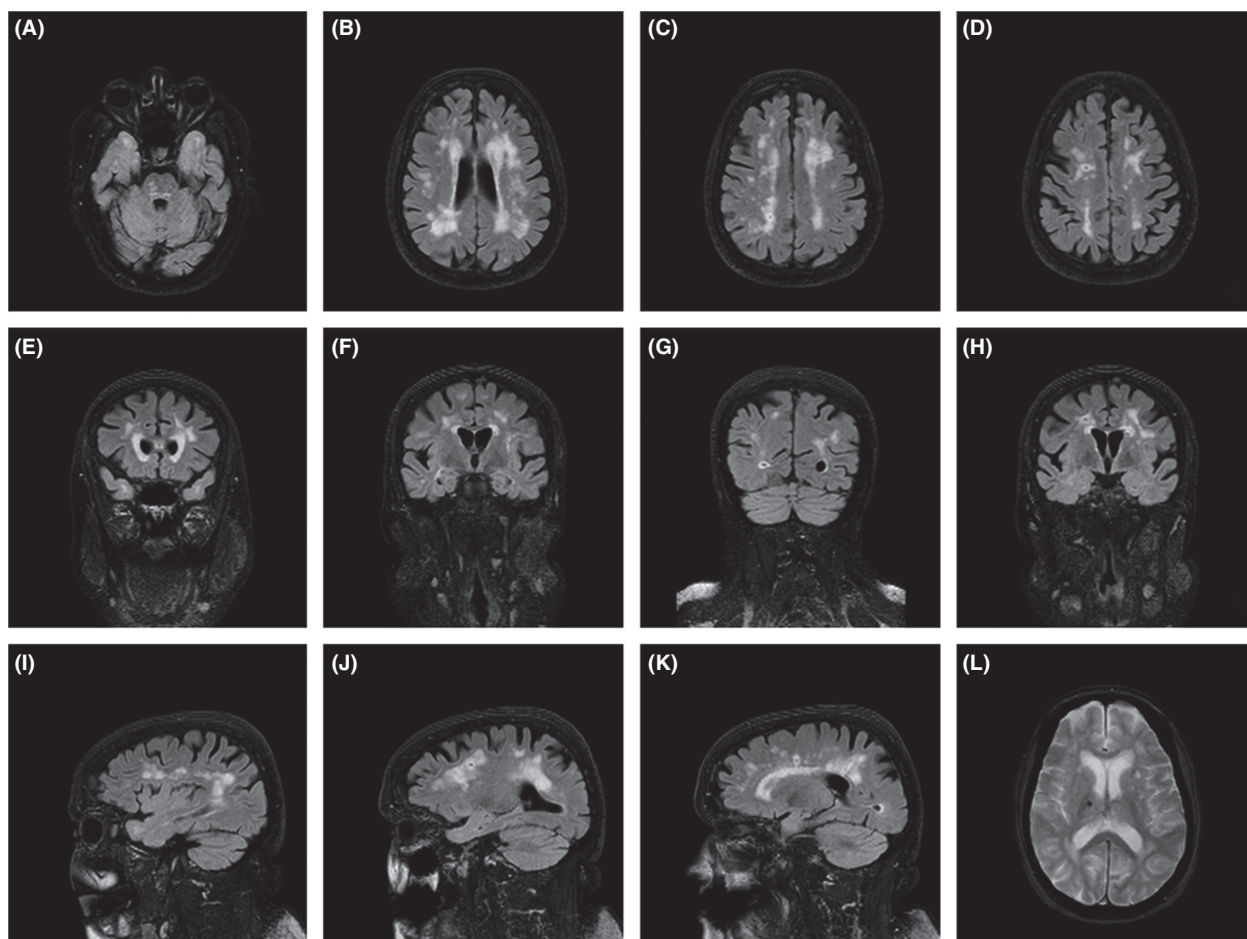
Brain MRI findings of the proband. The FLAIR images (A–K) demonstrated the multifocal damage of the white matter involving the brainstem (A), the temporal poles (A, E, I), the left external capsule (F), the periventricular regions (E, J, K), the subcortical regions apparently sparing the U-fibers (B–K). The gradient-echo image (L) showed one microbleed in the right basal ganglia region.
